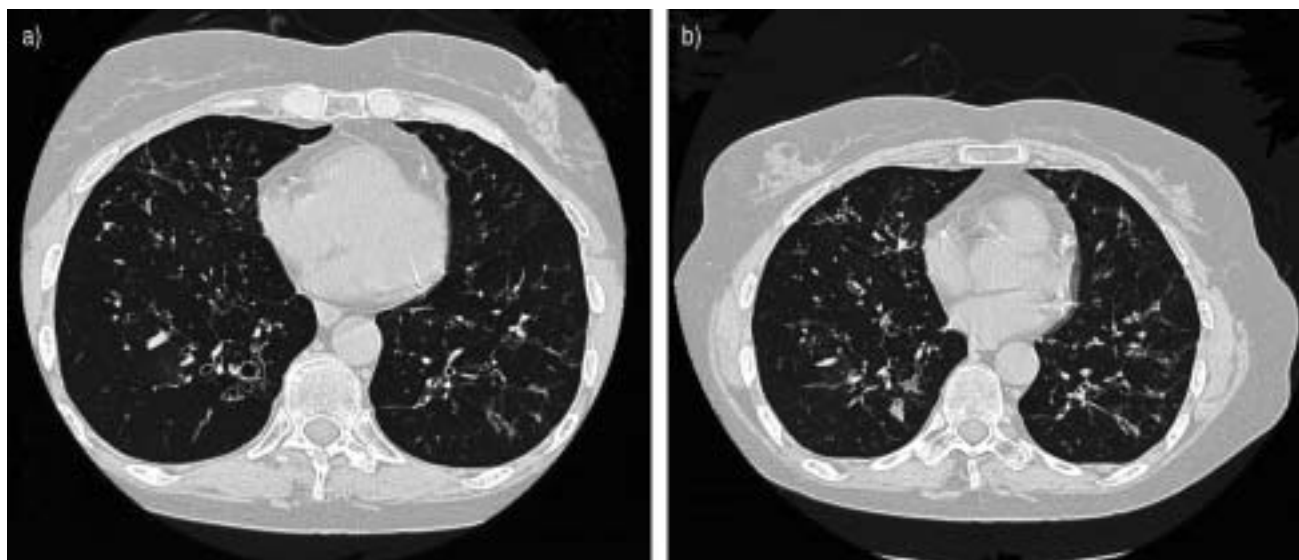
High-resolution computed tomography scan of chest performed at a) inspiration and b) expiration.
